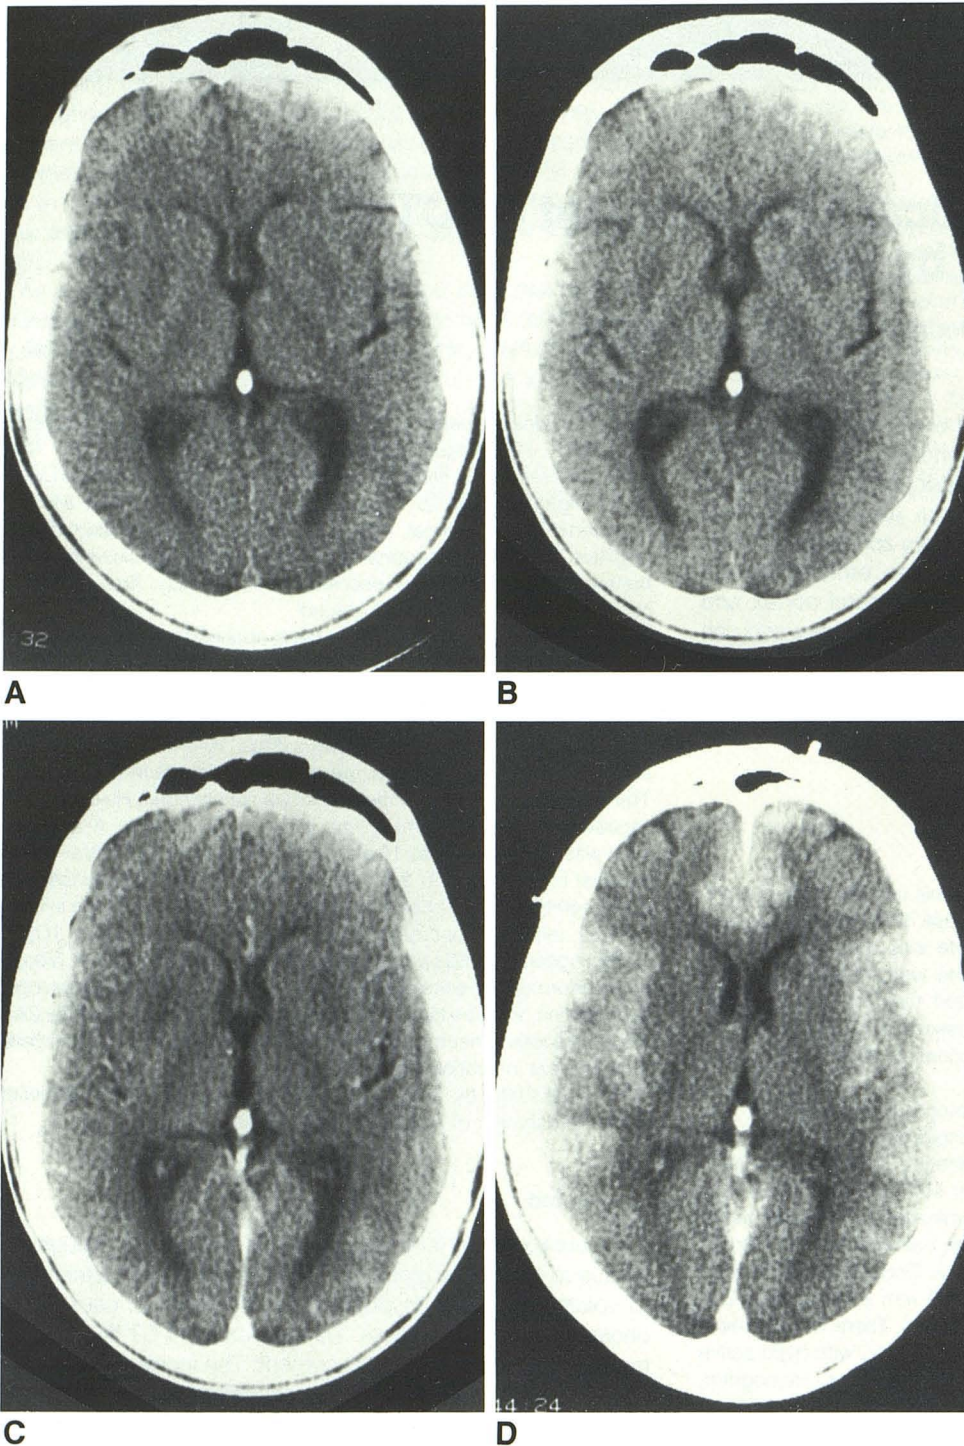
Sequential axial CT scans at approximately the same level.
